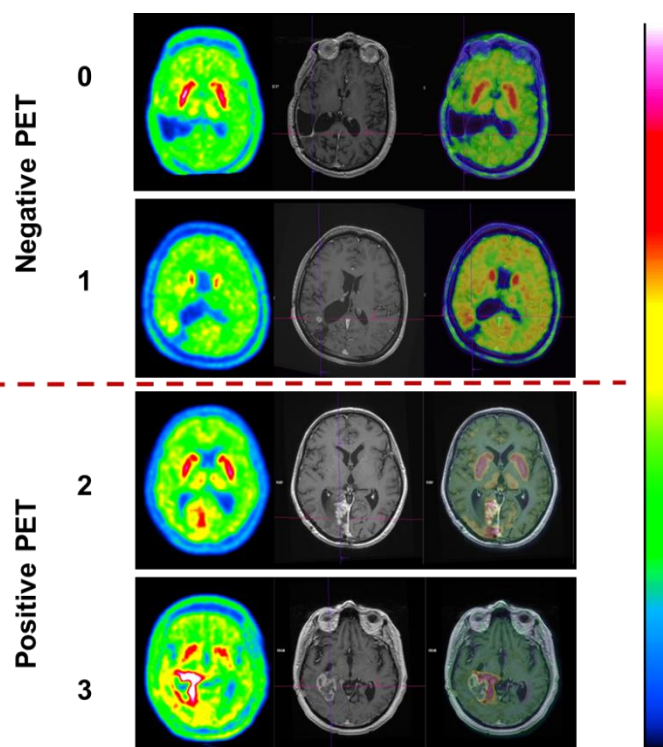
Visual interpretation of PET, ^{18}F DOPA PET image on the left. T1-enhanced MRI sequence with gadolinium contrast emphasized in the center. ^{18}F DOPA PET / MR image fusion right. The ^{18}F DOPA-PET
